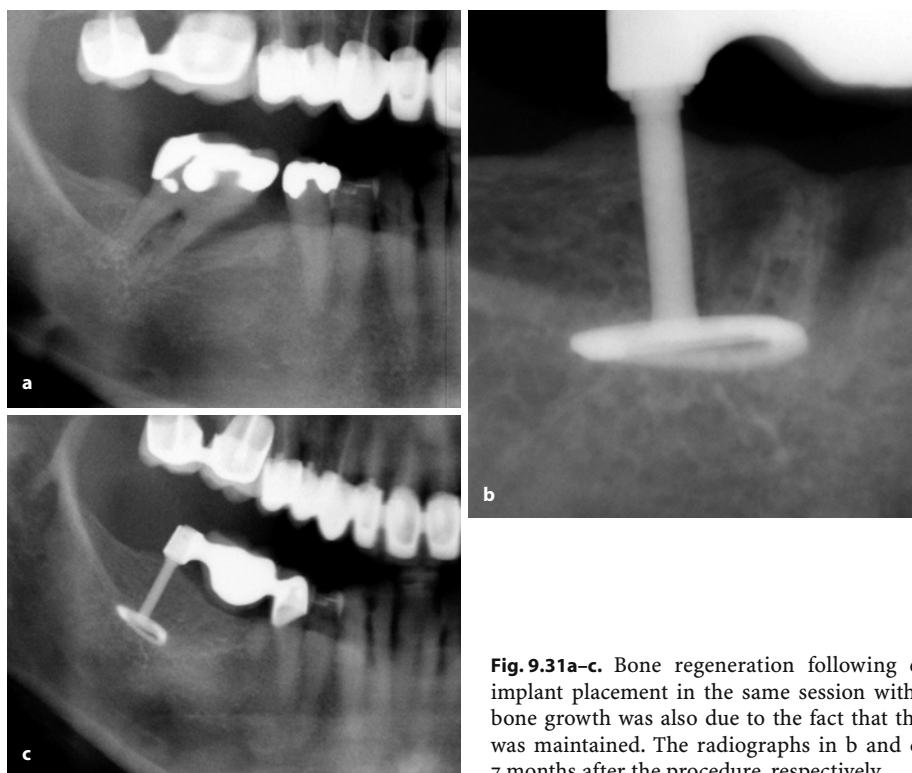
Bone regeneration following extraction of tooth 47 and implant placement in the same session with immediate loading. Vertical bone growth was also due to the fact that the preferred left working side was maintained. The radiographs in b and c were obtained 4 weeks and 7 months after the procedure, respectively
